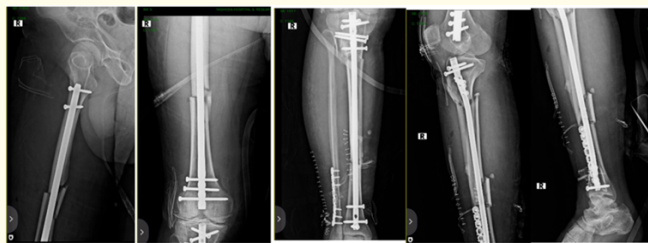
Immediate post op x-ray images.
